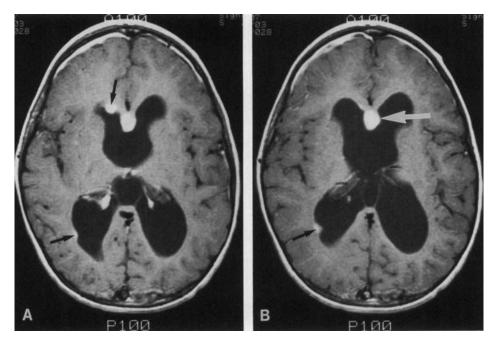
Post-contrast axial T1-weighted images (A,B) at the level of the lateral ventricle performed on patient in Case 3 in March 1993, immediately prior to commencement of cyclphosphamide therapy, show a 1.5×1.0 cm enhancing module (white arrow) adjacent to the genu of the corpus callosum. Several ependymal metastatic nodules are also identified (black arrows).
